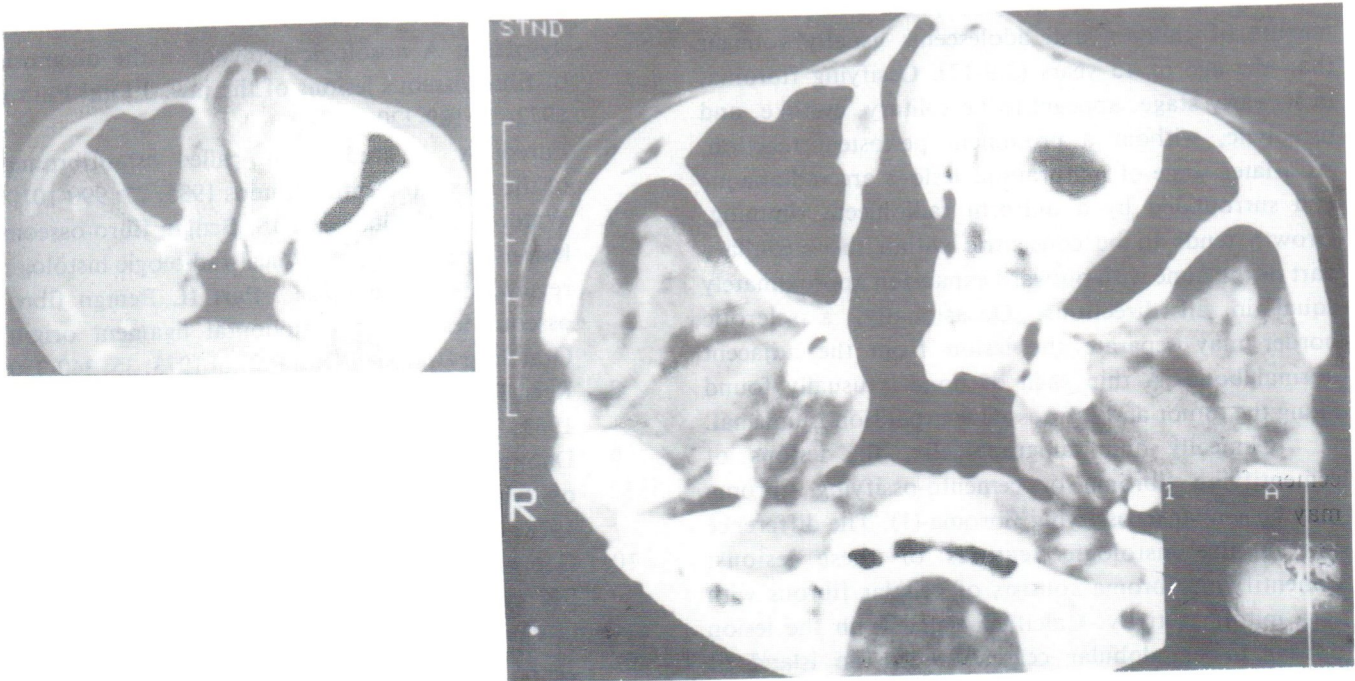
Case 3. Axial CT scan of the mass showed a densely calcified or ossified mass in the left nasal cavity, left maxillary-frontal sinus, and medial left orbital cavity. Lack of destructive behavior was obvious, which was similar to the lesion of Case 1.
